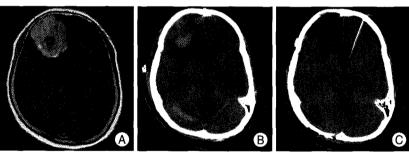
A : Preoperative gadolinium-enhancement MRI demonstrating a well-enhancing extra-axial mass at the right frontal convexity. B : CT scan 6 hours after surgery revealing intracerebral hematoma at the operative site along with RCH in the right cerebellar hemisphere and both superior cerebellar folia. C : Encephalomalacia at the site of previous hemorrhage on the right cerebellum 1 month after surgery. RCH : remote cerebellar hemorrhage.
